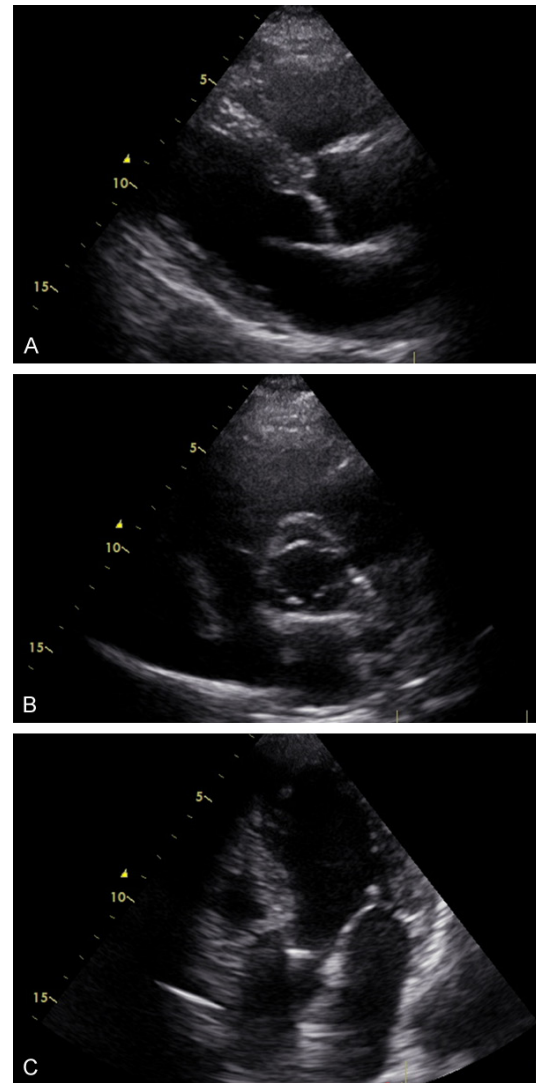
A. Parasternal short-axis images of the aortic sclerosis. Calcification and thickening of the aortic root and leaflets. B. Parasternal short-axis images of the aortic sclerosis. AS without obstruction of the left ventricular outflow. C. Apical four chamber view of the aortic sclerosis.
